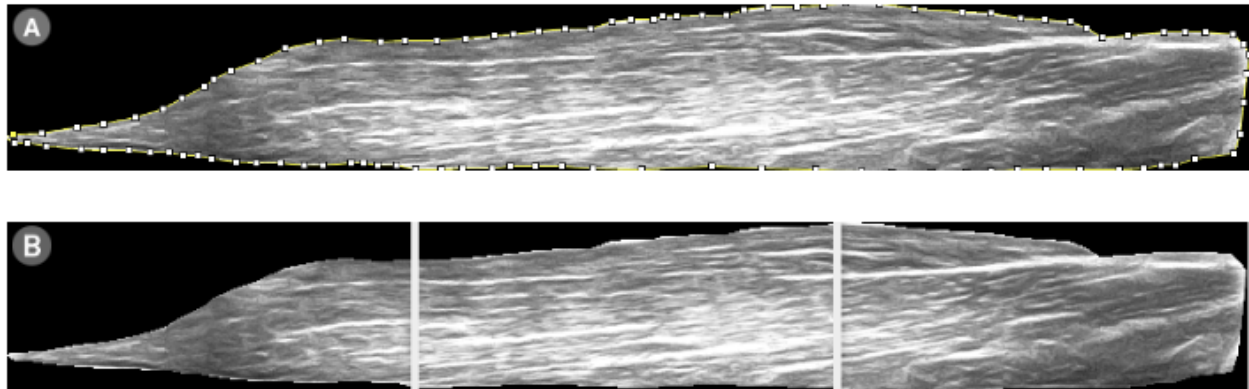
Panoramic b-mode ultrasound scan of the elbow flexors. The left side of the images show the proximal region of the elbow flexors and the right side of the images show the distal region of the elbow flexors. The first (a) and second (b) scans were performed at the same time point but some variation in the scans is visible.
